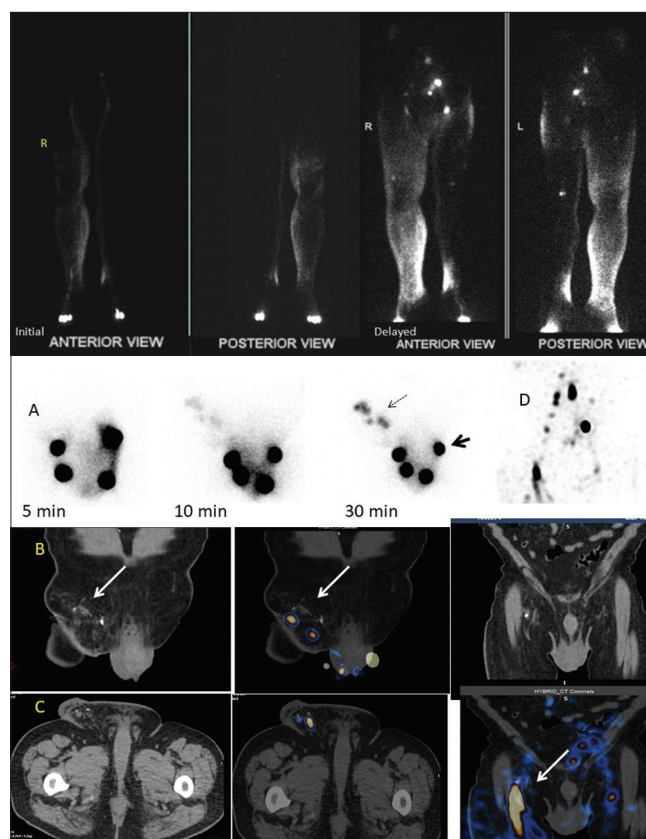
(Case III): (A) Multiple static pelvic images of ^{99m}Tc nanocolloid lymphoscintigraphy (Case III) done at 5 weeks postop. Intradermal injection was performed at 4 locations at base of scrotum (bold arrow). (B) Faint arrow shows the colloid accumulation depicting sites of functioning micro lymph nodes transplanted along right groin in coronal images. (C) Fused coronal image clearly depicts linear colloid tract along medial aspect of right groin indicating possibly the micro lymphatic tract restoration. (D) MIP image
